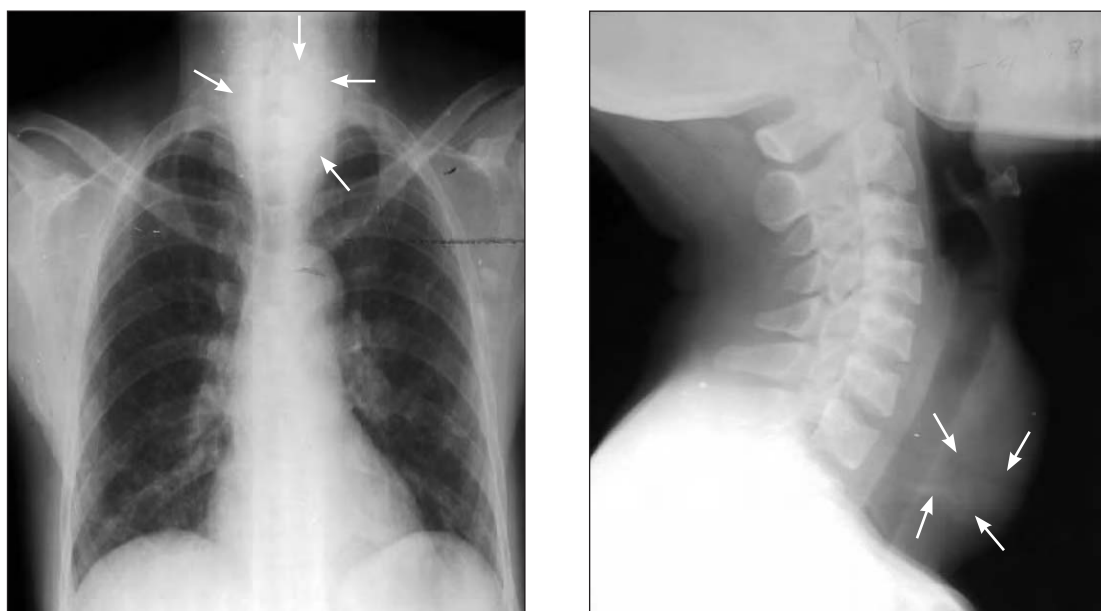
Frontal chest and cervical radiographs of a patient demonstrating cloudy calcification. Note the lobulated mass in the left hilum
